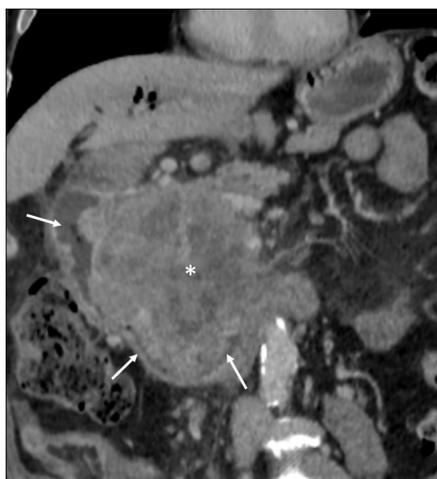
Curved-coronal reconstructed contrast-enhanced CT image shows pancreatic tumor (*asterisk*) progression within duodenum (*arrows*).
